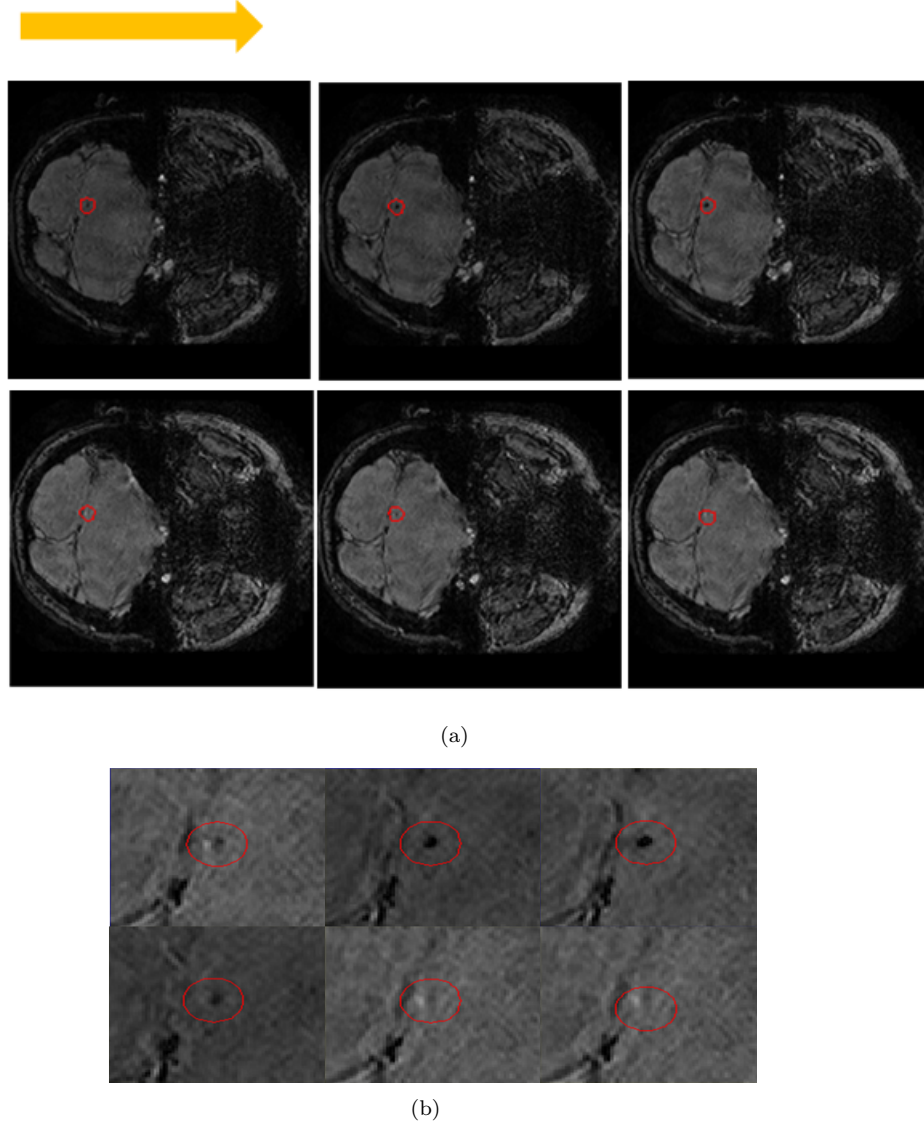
Microbleed (a) the axial view of T2*-weighted brain MRI in 6 continuous slices which shows the CMBs as black regions of the image indicated by red circle. The spherical character of CMBs can be seen by observing these continuous slices (The slices are sorted from left to right) (b) for a more clear observation the region of interest where the CMBs are located is enlarged. The arrow depicts the direction for following the sequences from top to bottom.
